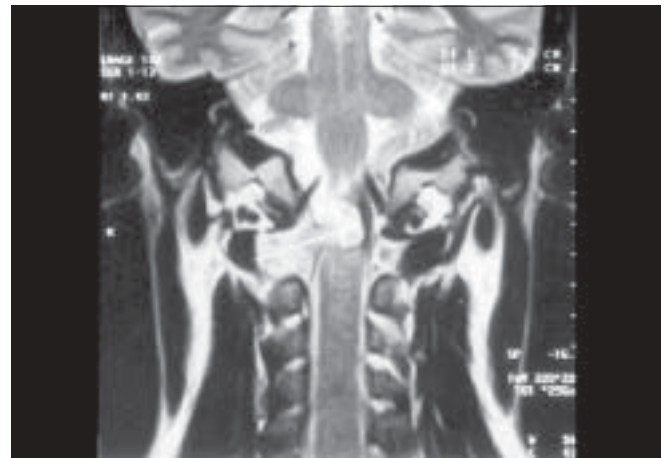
T2 weighted coronal section of MRI craniocervical junction showing posterolateral dumbbell-shaped hyperintense tumor compressing the cord to opposite side
